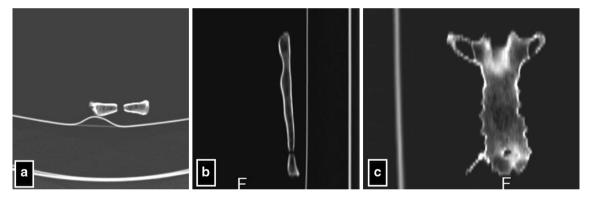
Computed tomography scanning of the sterna presenting SF at the SF level. a Axial section showing "bow-tie" formation, b sagittal and c coronal reconstruction showing the SF as a defect
